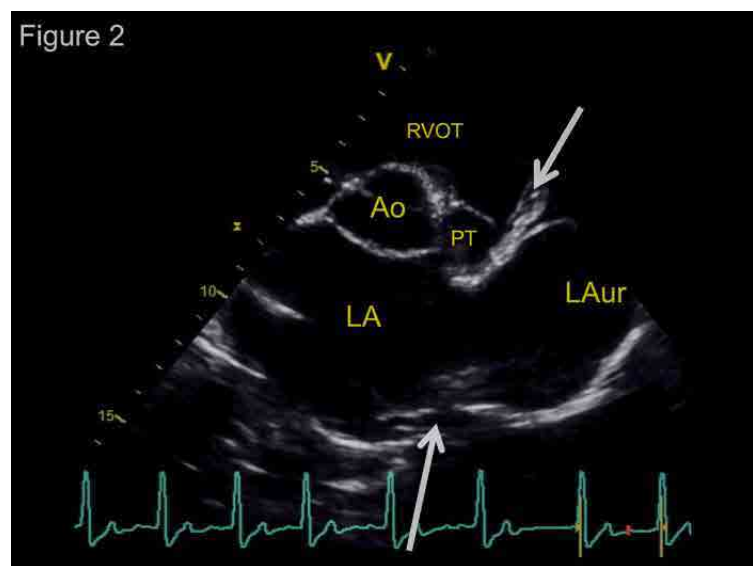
Bidimensional right parasternal transaortic short-axis view showing the left atrial (LA) and left auricular (LAur) dilation, with constriction of the basal portion of the LAur at the level of the pericardial defect (arrows) and LAur herniation. Ao, aorta; PT, pulmonary trunk; RVOT, right ventricular outflow tract.
